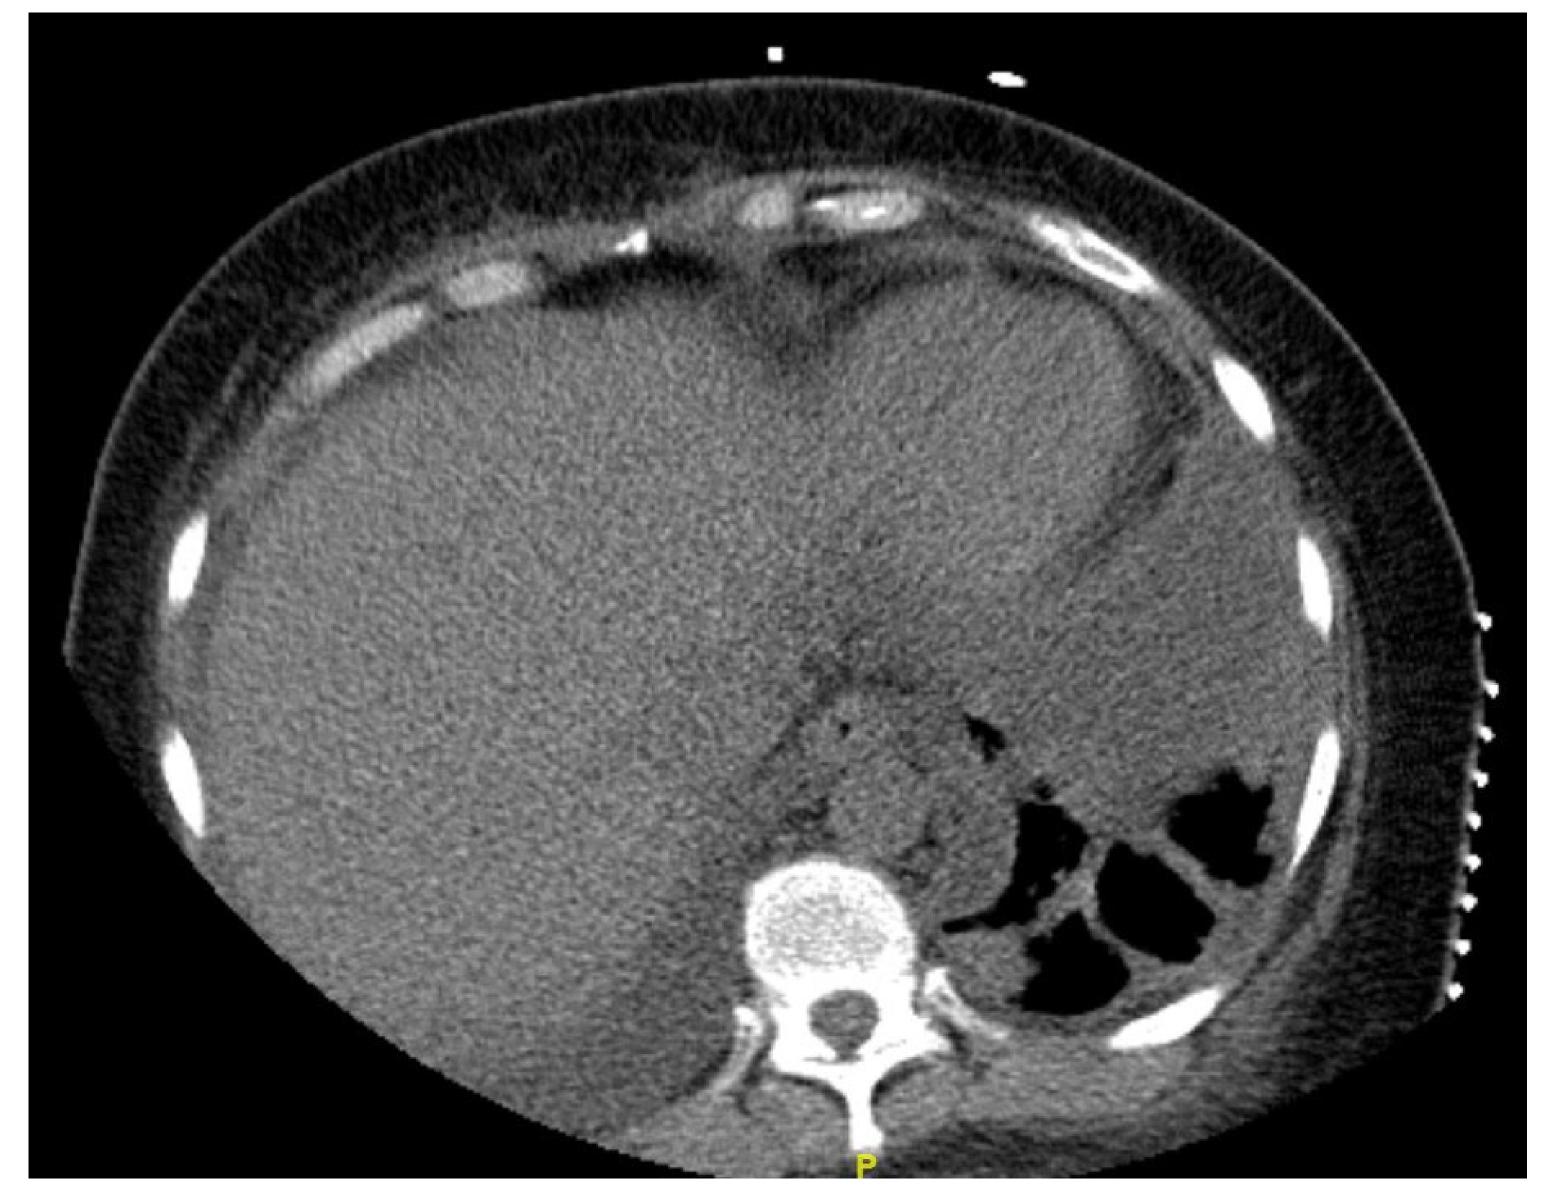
CT Chest prior to insertion of Chest Tube
